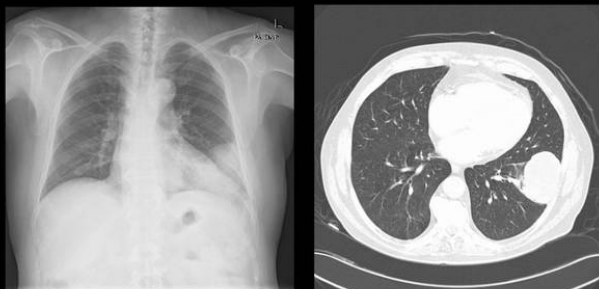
Frontal chest radiograph and axial CT image demonstrating a large left lung metastases.
